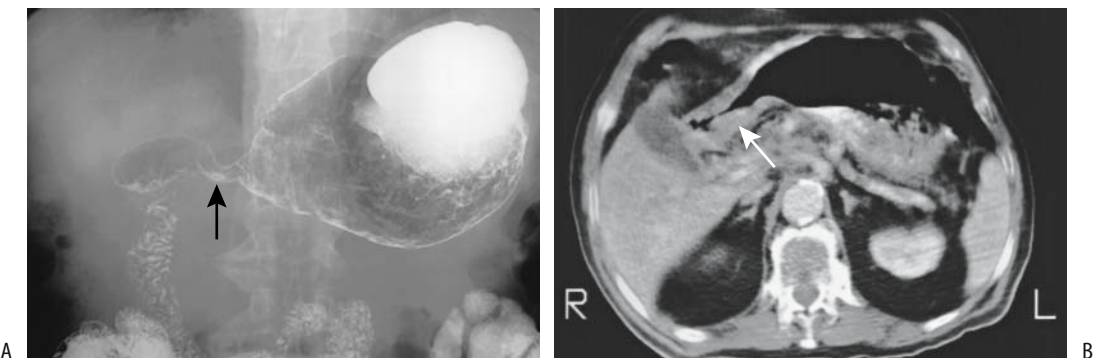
Antral adenocarcinoma. A barium study (A) and computed tomography (CT) (B) detect marked antral infiltration (arrow). (Courtesy of David Katz, M.D., University of Massachusetts.)
